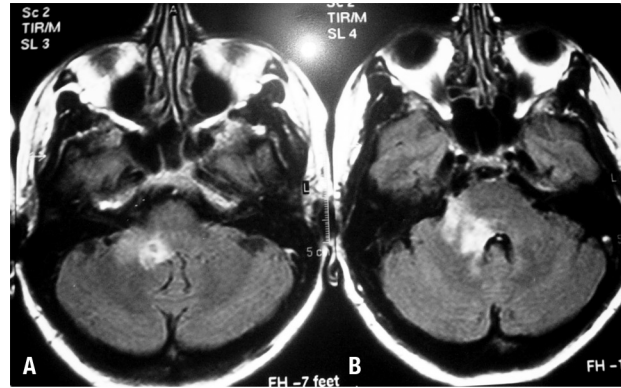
MRI- T2-weighted images [A, B], FLAIR [C, D, and E], T1 with gadolinium enhancement [F].
